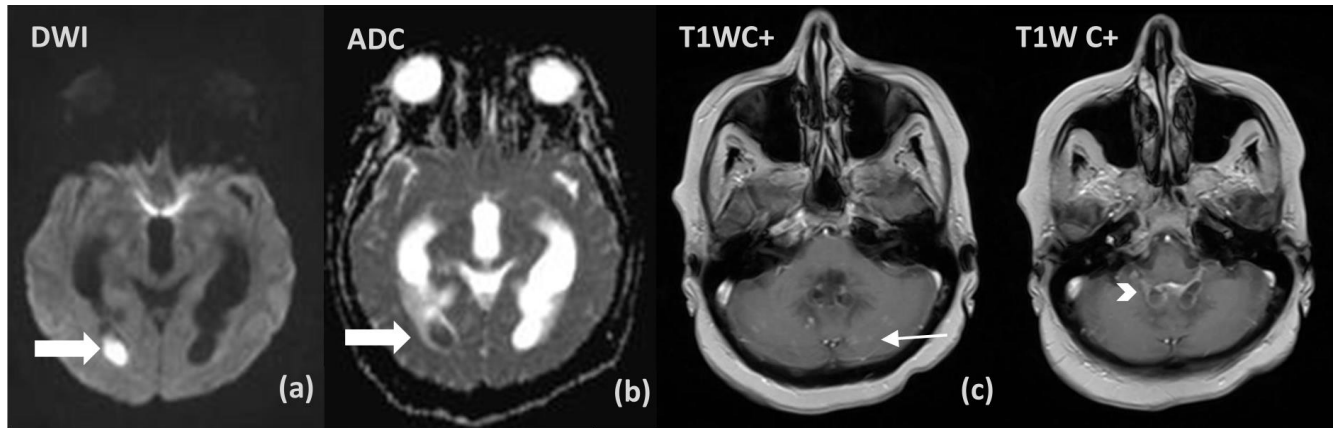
MRI brain axial images showing diffusion restriction in the occipital horn of right lateral ventricle as shown thick arrows (a, b). Patchy areas of postcontrast enhancement seen in bilateral cerebellar hemispheres as shown by arrow (c). Enhancement of basal cisterns and bilateral foramina of Luschka meninges also noted shown by arrowhead (d).
